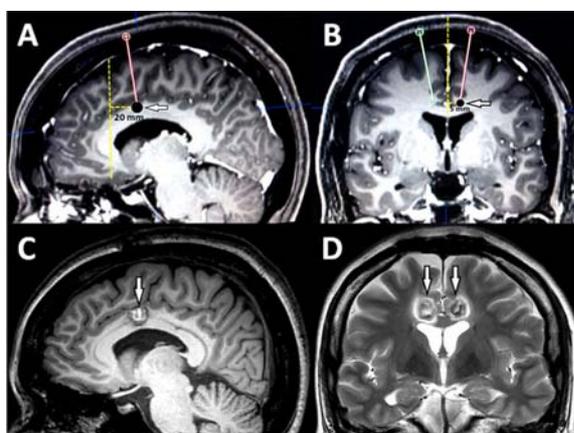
Preoperative planning for stereotactic bilateral anterior cingulotomy and postoperative MRI: (A) preoperative sagittal T1WI showing a target for anterior cingulotomy (arrow) located at 20 mm posterior to the anterior end of lateral ventricle; (B) preoperative coronal T1WI showing the target (arrow) located at 5 mm lateral to the midline; (C) postoperative sagittal T1WI showing a large lesion at the anterior cingulum (arrow); (D) postoperative coronal T2WI showing large lesions at the bilateral anterior cingulate cortex (arrow).
